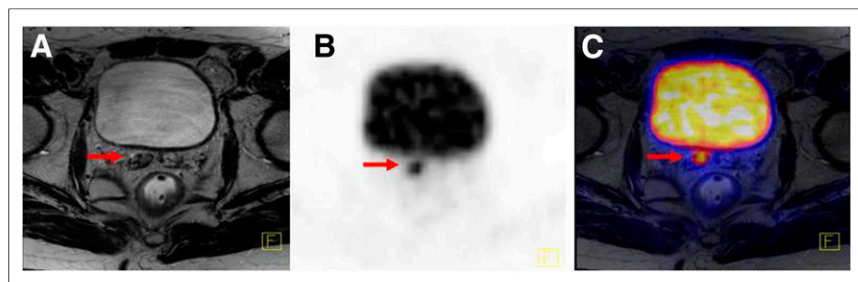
Axial ^{68}Ga -PSMA PET/MR images of 63-y-old patient with recurrent prostate cancer with hypointense signal alterations in T2w images (A, arrow) and intense focal ^{68}Ga -PSMA uptake in right seminal vesicle of PET part of PET/MR (B, arrow) and in fused PET with T2w images (C arrow).
